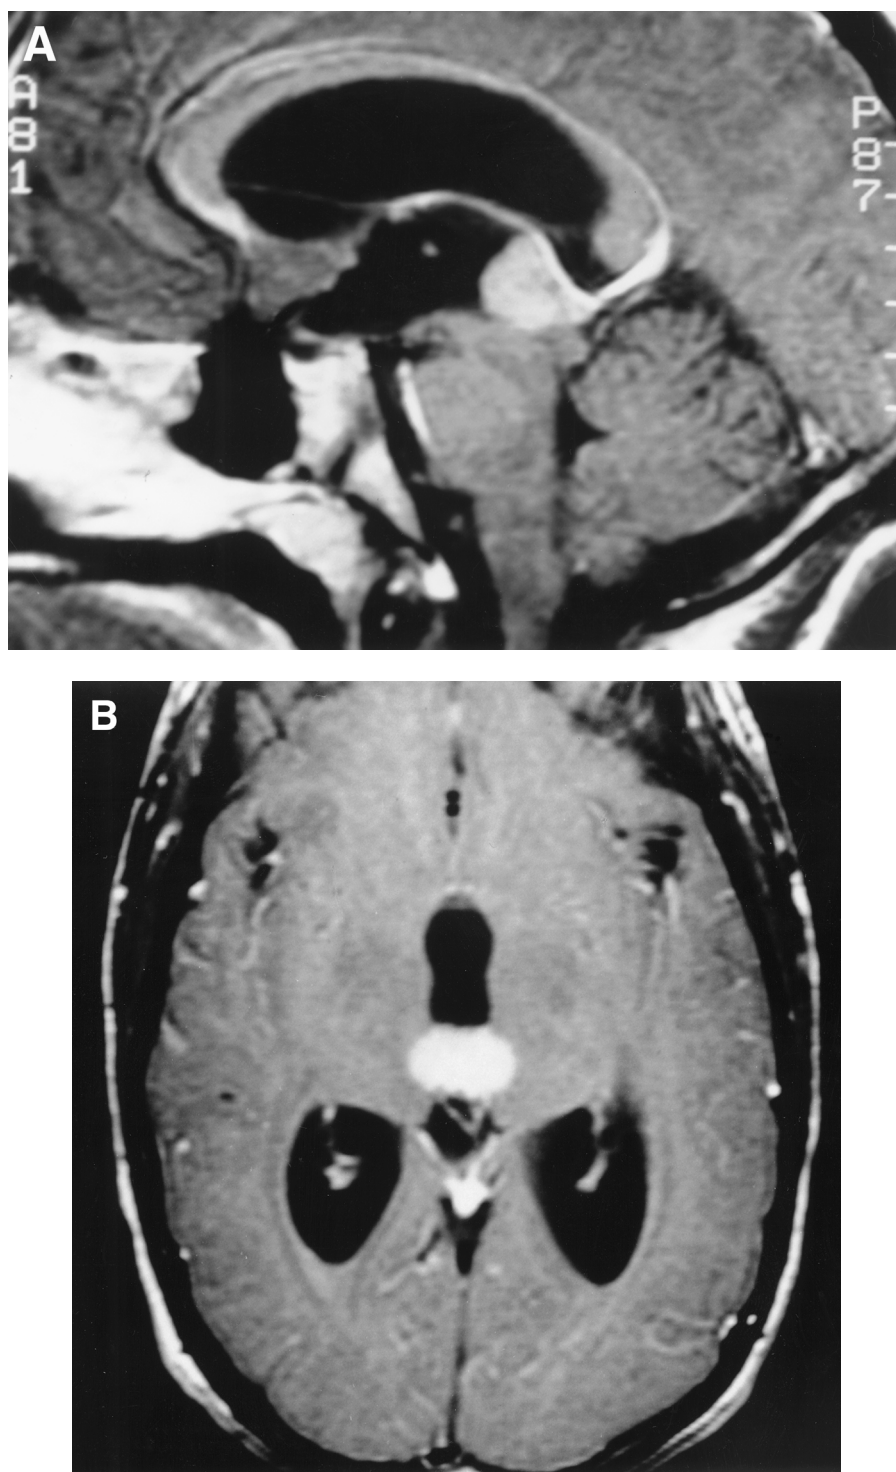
(A) Sagittal MRI scans with contrast of an 18-year-old man who presented with symptoms of increased intracranial pressure. The MRI shows a homogeneously enhancing pineal mass causing obstruction of the aqueduct of Sylvius. (B) Axial MRI of same patient. (C) Intraoperative photograph showing what turned out to be a germinoma. The superior colliculi are seen just inferior to the tumor. (D) Sagittal MRI 3 months after surgery and radiation therapy; no evidence of residual tumor is shown. (*continued*)
